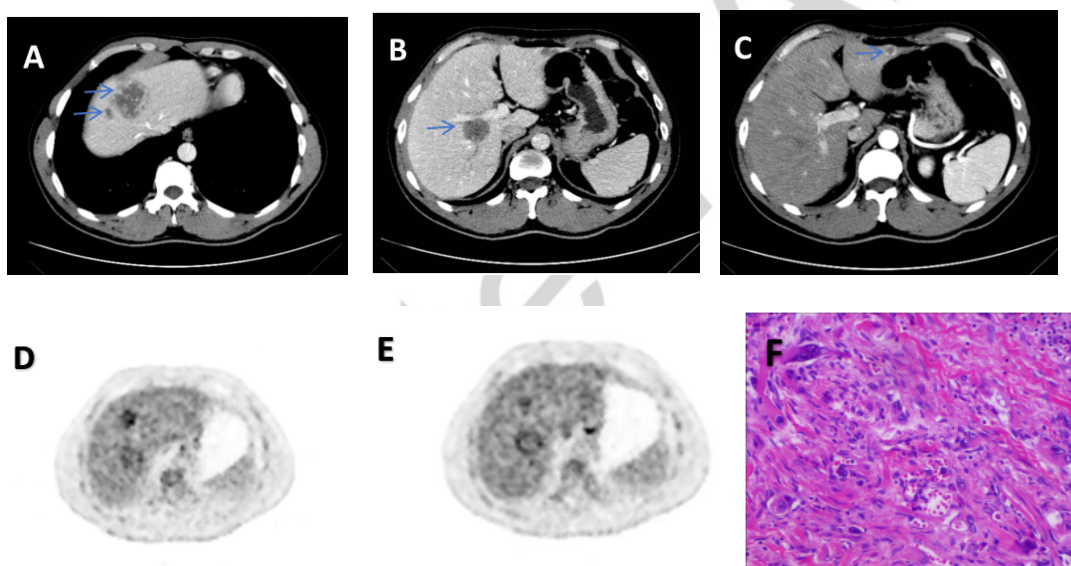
33-year-old male patient with primary hepatic epithelioid hemangioendothelioma. A-C. CT-enhanced arterial phase. A. the S4a and S8 segments of the liver showed a round-like slightly low-density lesion with a blurred edge. The size was about 47mm × 44mm, and a few calcifications were seen in it. The enhanced scan showed progressive enhancement. B. the S7 segment of liver showed a round-like slightly low-density lesion. C. the S3 segment of liver showed a round-like slightly low-density lesion. D-E. PET / CT showed multiple slightly low-density nodules and masses with different sizes in the center of the liver, with a small amount of punctate calcification, adjacent to the hepatic capsule depression, forming a typical 'halo sign'
